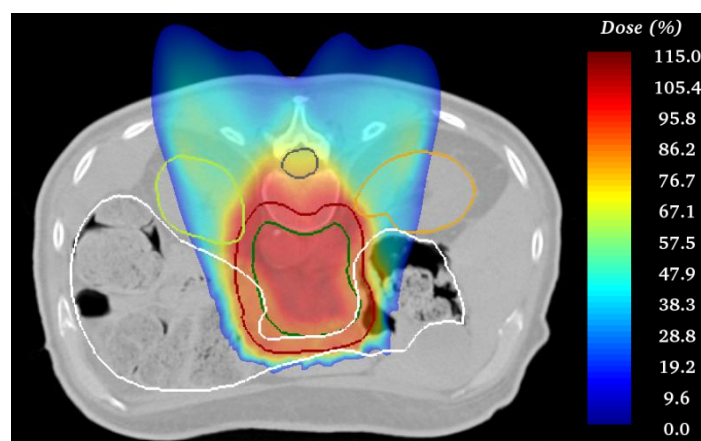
Dose distribution of a planning-CT for Patient J. (Contoured OARs and target volumes: grey = spinal cord, lime = left kidney, mustard = right kidney, white = bowel, green = CTV, red = PTV)
